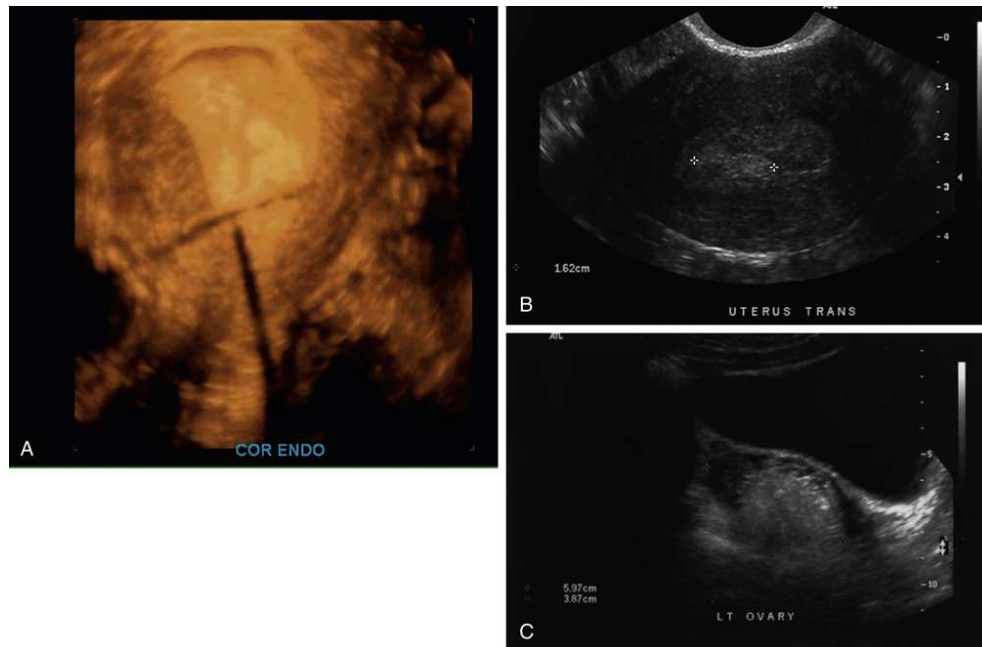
(A) Volumetric coronal sonogram of uterine cervix showing improper location of an intrauterine device. (B) Coronal image of the endometrium showing a hyperechoic neoplasm (calipers). (C) Sagittal image of complex left ovarian mass. A and C, Courtesy Paul Aks, BS, RDMS, RVT.
